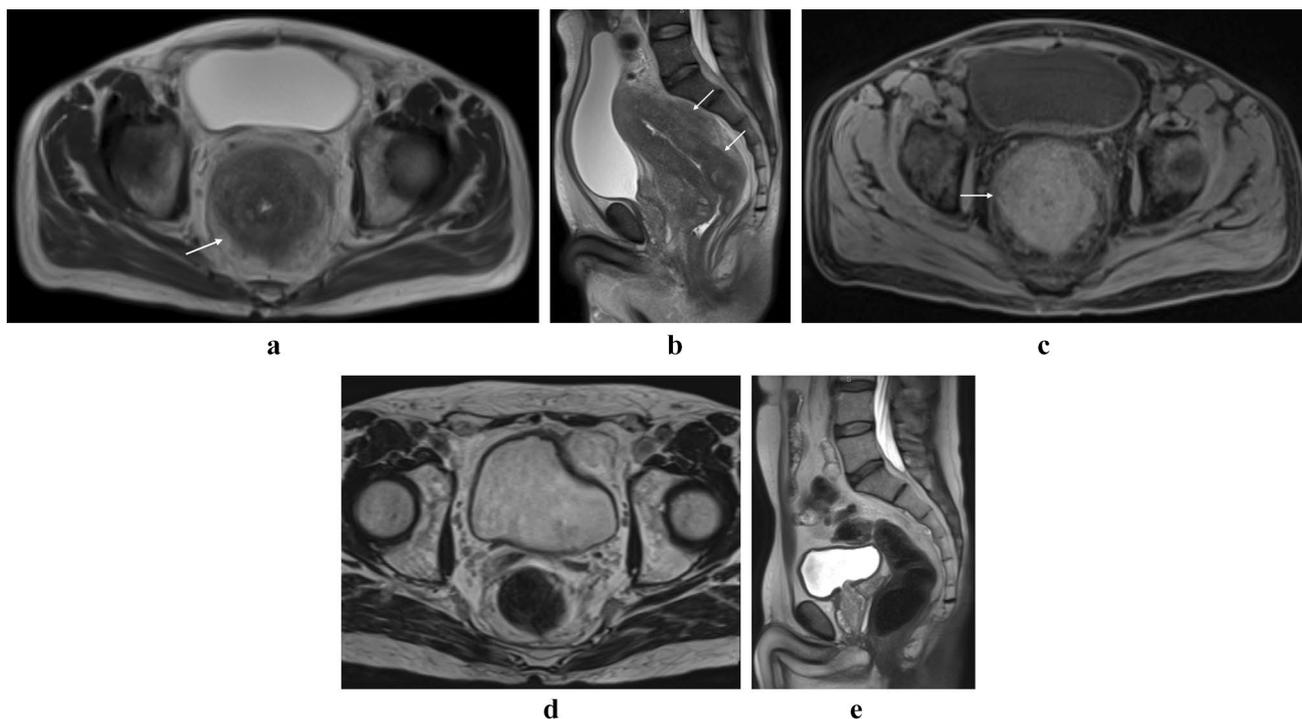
Basidiobolomyces. A rare fungal infection, more common in the south-west US, mimicking a circumferential rectal mass. Axial and sagittal T2-weighted images show the mass before treatment (a
